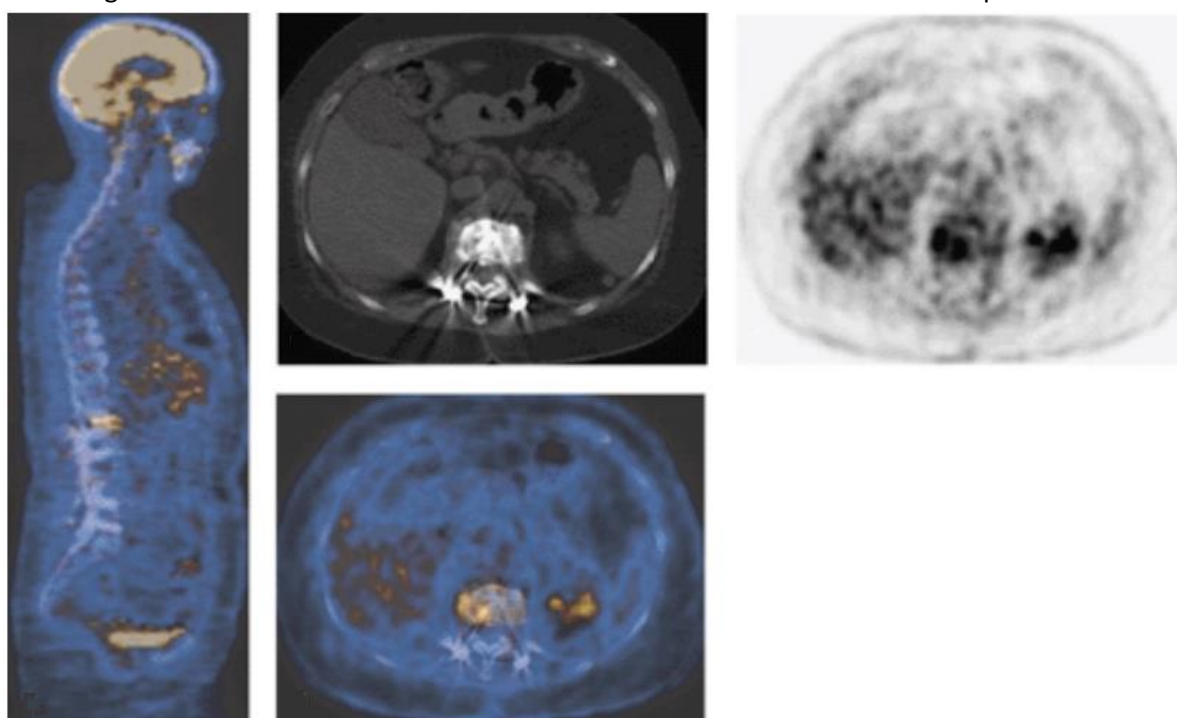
PET/CT of low grade infection 2 years after decompression and instrumented spondylodesis of L1/L2. There is an increased FDG uptake in the region of the right cranial screw in the L1 vertebral body corresponding to osseous infection.
